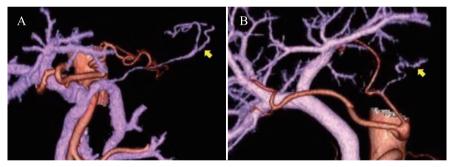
Gastric drainage veins following TP depicted by 3D-CT. Panel a shows the posterior and short gastric veins and the splenic vein as gastric drainage veins (yellow arrow) in patient 4. Panel b shows esophageal venous plexus enlargement to provide gastric drainage in patient 5.
